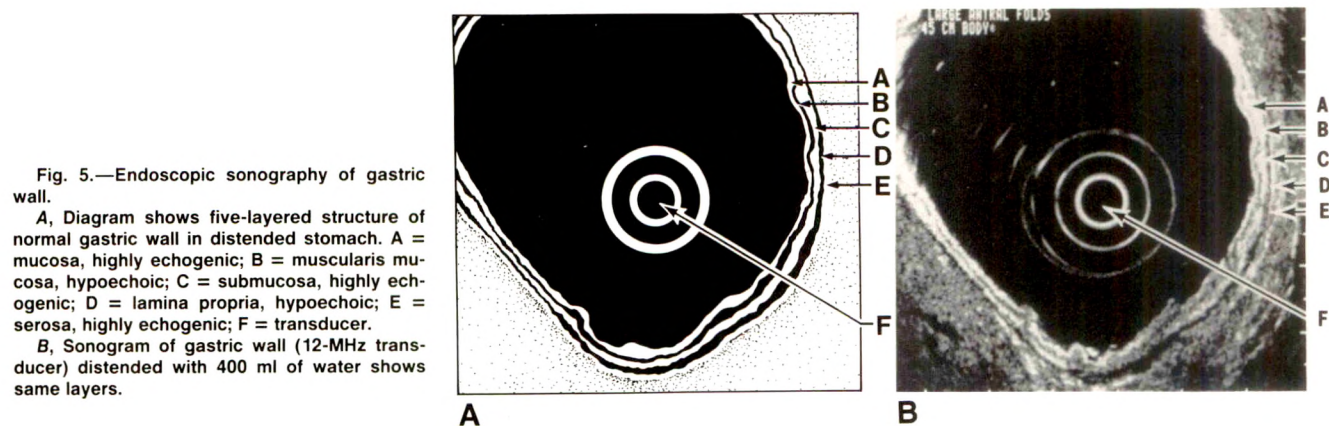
Endoscopic sonography of gastric wall.
